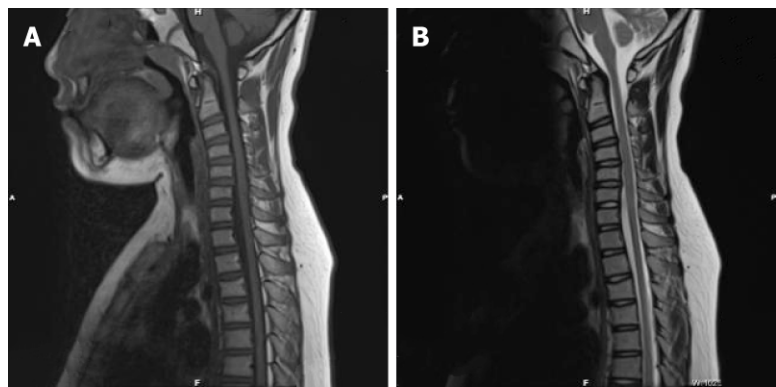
Magnetic resonance imaging showed the mild atrophy the spinal cord. A: T1 sagittal view B: T2 sagittal view.
